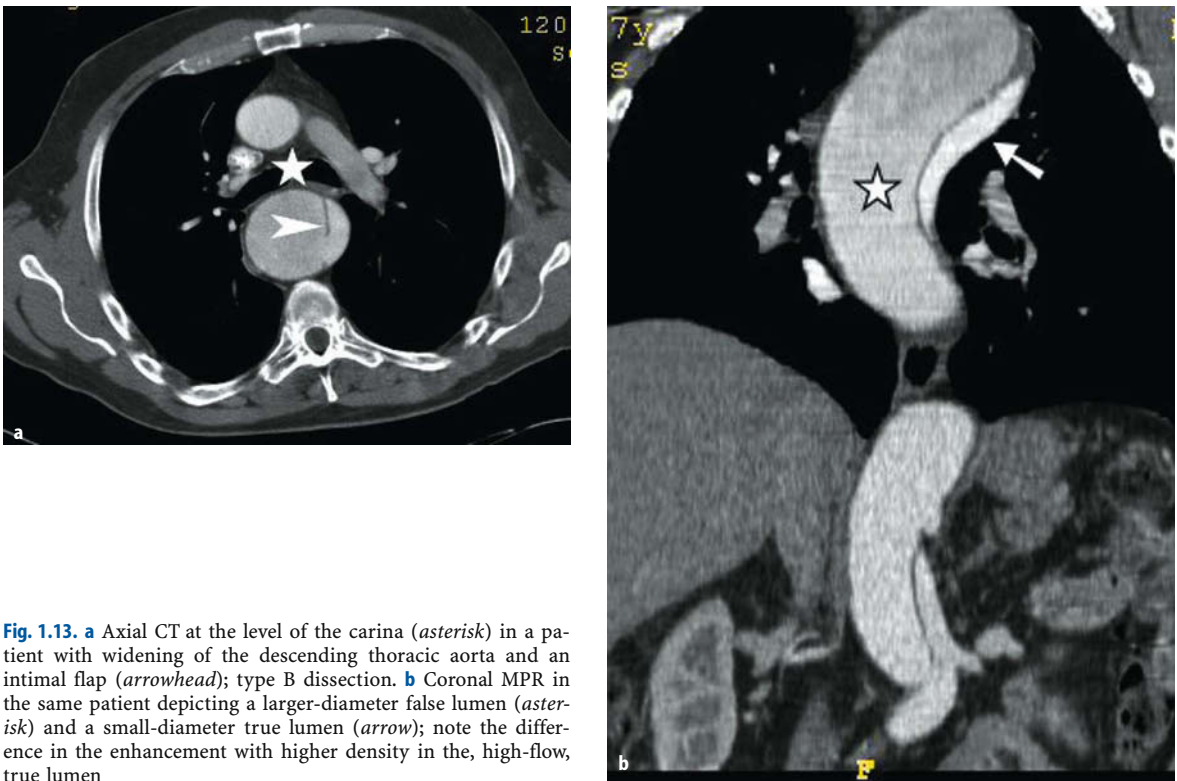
a Axial CT at the level of the carina (*asterisk*) in a patient with widening of the descending thoracic aorta and an intimal flap (*arrowhead*); type B dissection. b Coronal MPR in the same patient depicting a larger-diameter false lumen (*asterisk*) and a small-diameter true lumen (*arrow*); note the difference in the enhancement with higher density in the, high-flow, true lumen
